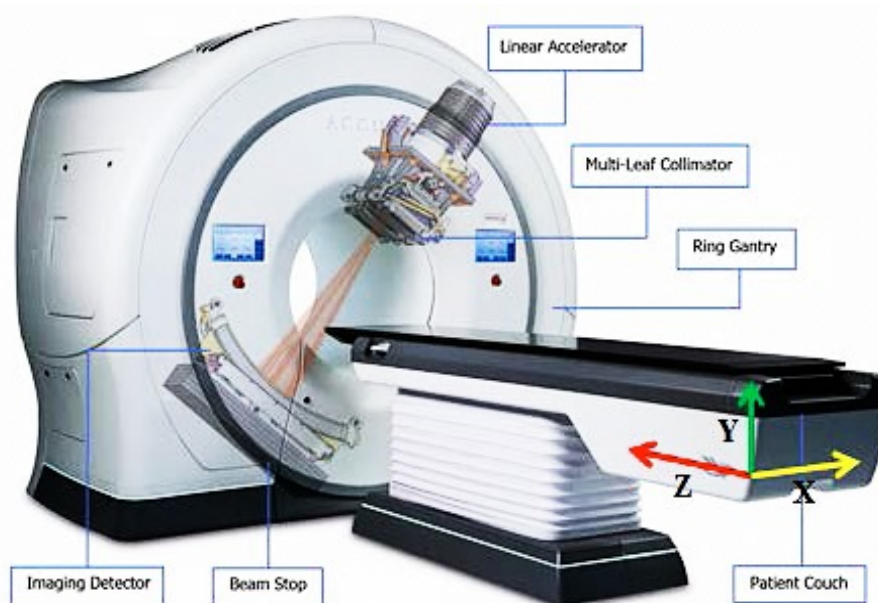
Left: *Aquilion Large Bore CT system* Right: *TomoTherapy® Treatment system unit*
